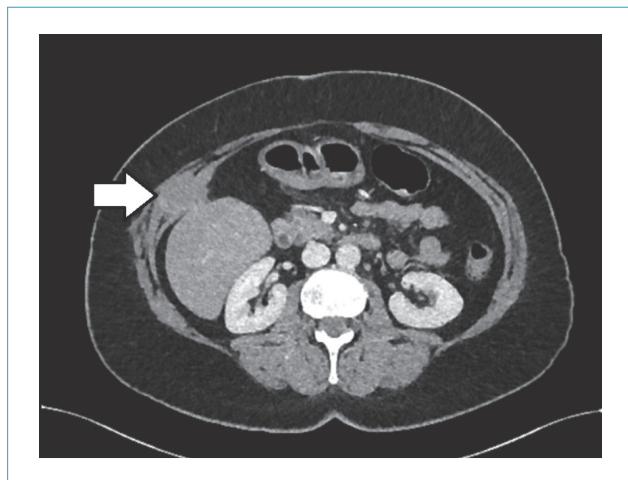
Abdominal contrast-enhanced computed tomography (venous phase) of a 59-year-old patient with a history of lung carcinoma. There is solid lobulated mass with homogeneous diffuse contrast enhancement in the anterior abdominal wall muscles. According to the results of fine needle biopsy, metastasis of lung carcinoma (data obtained by the authors of the article)
